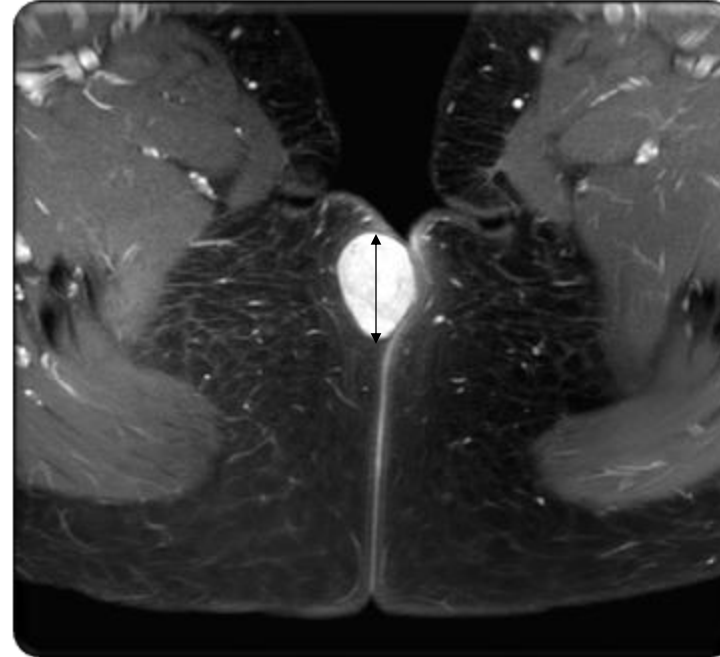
and 2 depict magnetic resonance imaging of the perineal mass.
